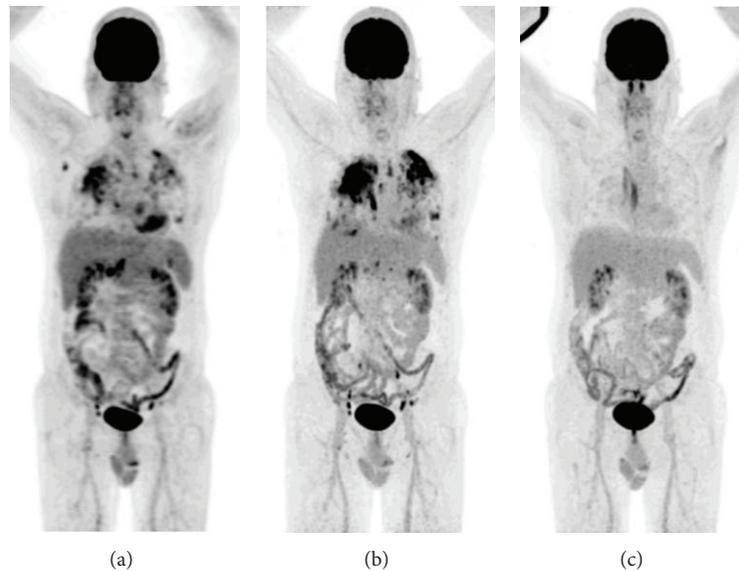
An example of the value of FDG-PET/CT in a patient with sarcoidosis: (a) baseline scan, (b) scan after 3 months of corticosteroid therapy with progression of lung infiltration, and (c) scan after 3 months of treatment with corticosteroids and methotrexate together, resulting in complete remission (the linear uptake is located in a muscle in the back and considered physiological muscle uptake).
